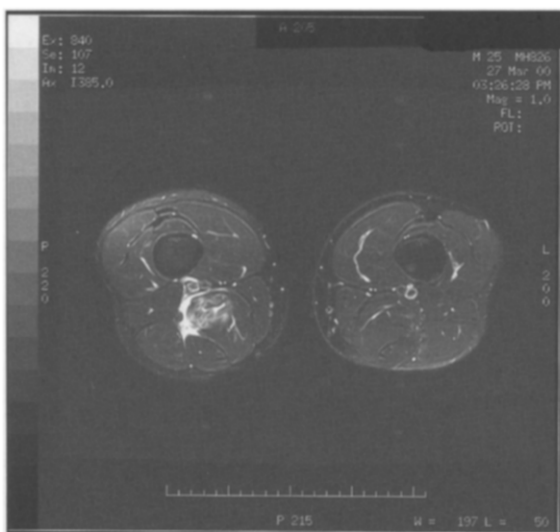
MRI positive scan showing a single muscle SM strain.
